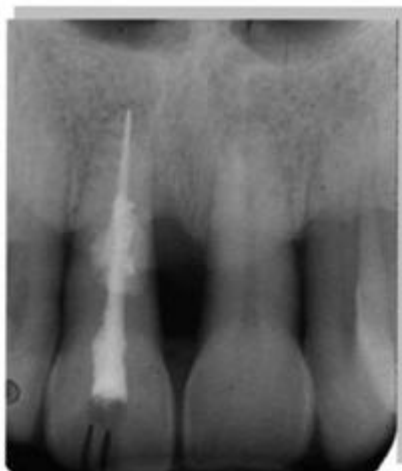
Radiographic examination showed that the defect was filled by about 80 %
